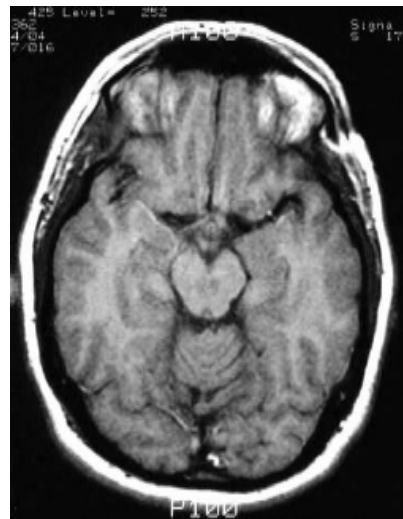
Axial MRI's (T1) showing a more ventral level of the temporal lobe as compared to figure . (From R, Swenson, Dartmouth Medical School)
